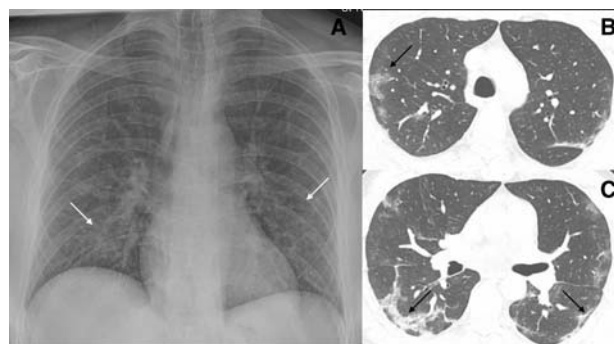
CXR (A) and CT (B & C) images of a 50-year-old man with 6 days history of fever and dry cough. RT-PCR test was positive. CXR shows bilateral diffuse opacities, with a more opaque patch in the right lower zone (white arrow). The corresponding CT shows the true extent of the disease (black arrows). Images reproduced with permission from Covid-19 Database of the Fleischner Society.
